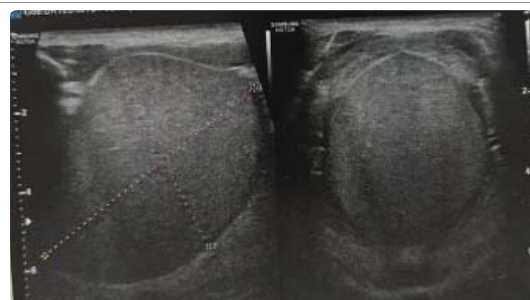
Ultrasonography showed a cystic formation in the floor of the mouth with a finely echogenic content, well limited, measuring 67x 52 mm.
